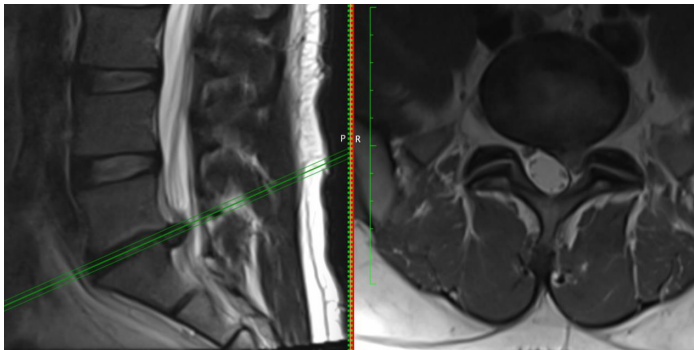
Original MRI of Lumbar spine that was done within weeks of onset of symptom. See L5-S1 large, herniated disc fragment eccentric to the left causing significant central spinal canal and left L5 and S1 nerve roots compression.
